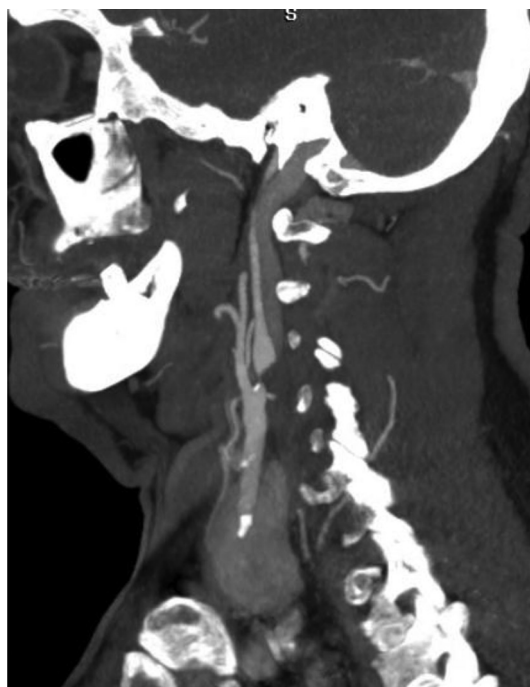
Sagittal CT-angiogram showing severe stenosis of the right carotid artery.
